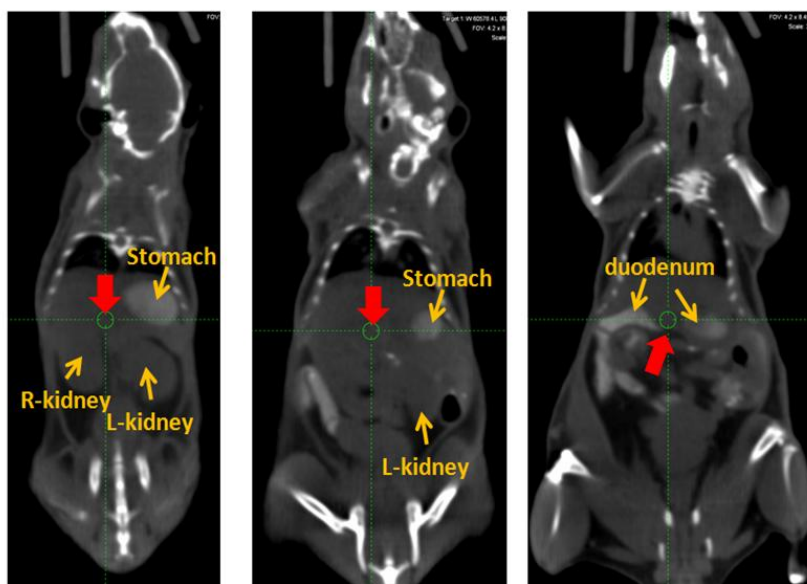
BaSO₄-enhanced CT for identification of pancreas area.
